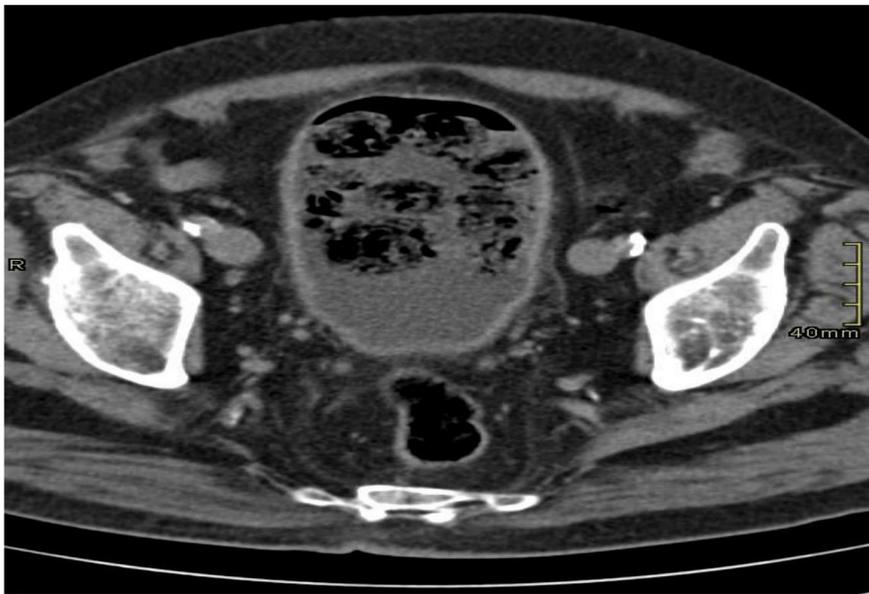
Axial reconstruction of an abdominal computed tomography scan. The bladder is filled with fluid and fecaloid material. A small amount of gas is seen in the anterior part of the bladder. The fecaloid material in the bladder is a fungus producing gas due to anaerobic metabolism.
